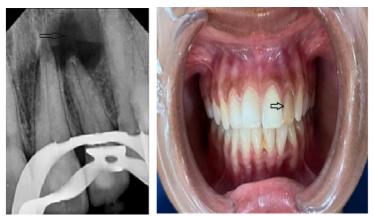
preoperative radiograph Figure 2 – preoperative clinical image
